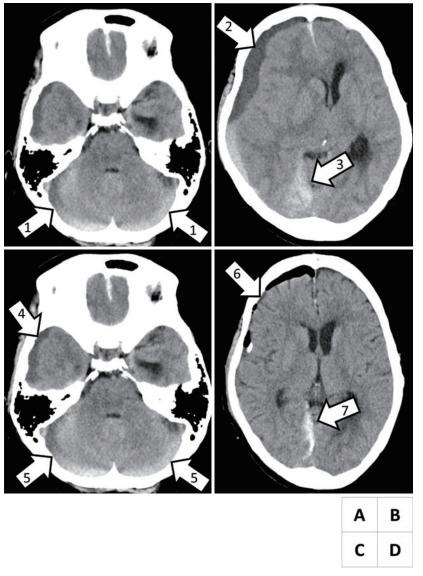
Computed tomography image of the present case.
